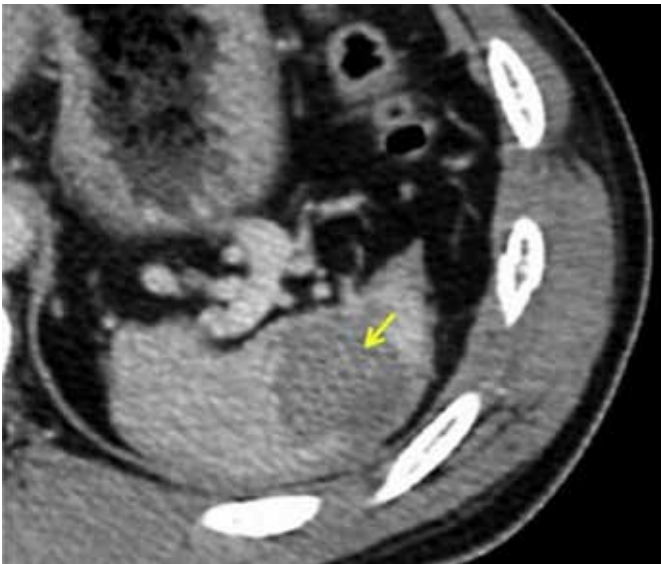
Blunt splenic trauma: intra-parenchymal hematoma. Computed tomography image<sup>4</sup>.
